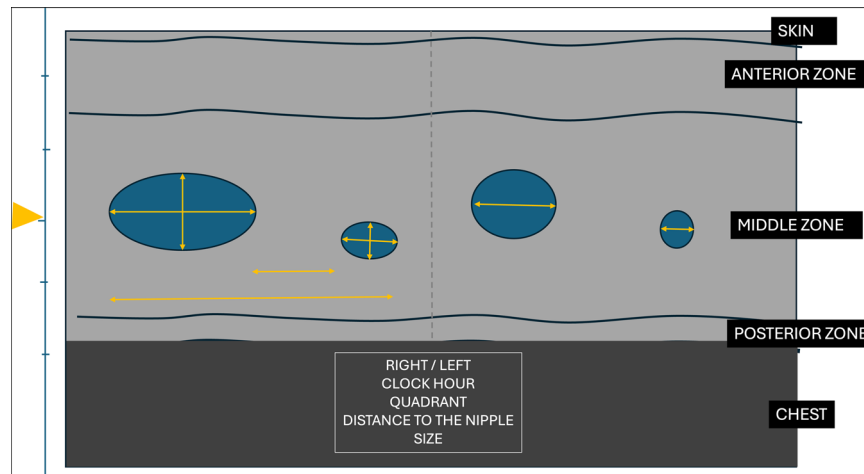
Quality criteria for US description of a mass. The arrow corresponds to the position of the focal point. The position of any lesion detected by ultrasonography should be detailed as follows: side, clock hour, quadrant, and distance to the nipple. For size, the different measurements need to be given: 3 axes (two orthogonal in longitudinal views (left part of the picture) and one in axial view (right part of the picture). When masses are multiple, intralesional and extreme external distances should also be precise
